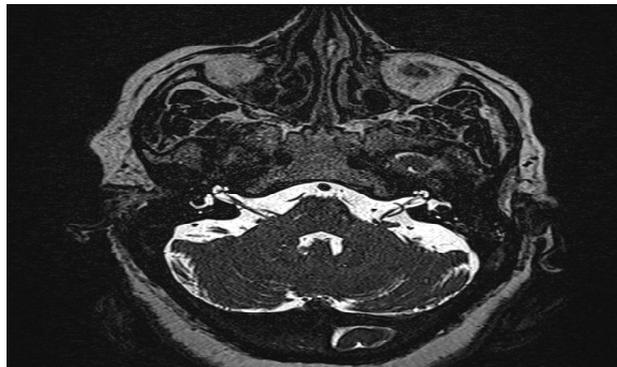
A brain MRI T2 3D constructive interference in steady state (CISS) shows the blood vessel (i.e. artery at the red arrow) looped around the vestibulocochlear nerve on the left side.
